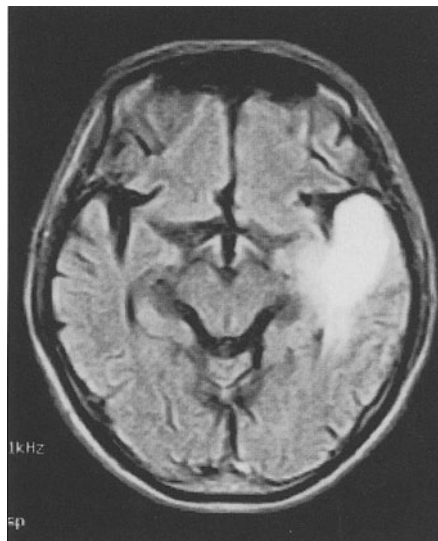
FLAIR sequence (TR 5500, TE 104, TI 1550) demonstrating “black CSF” and abnormal hyperintensity in the left temporal lobe on this heavily T2-weighted sequence. (Image from a GE 0.2-T open-design magnet)
